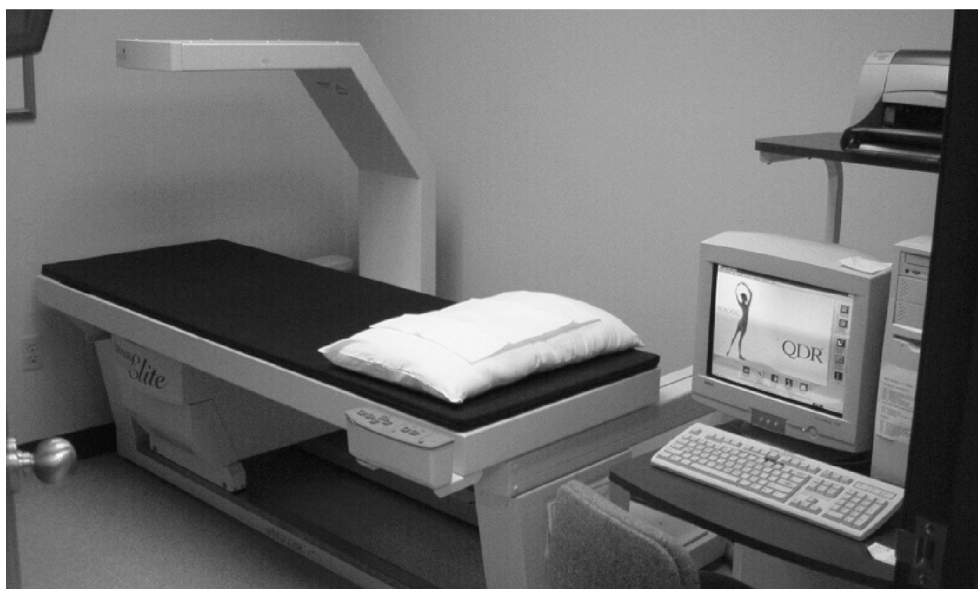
Dual-energy X-ray absorptiometer
